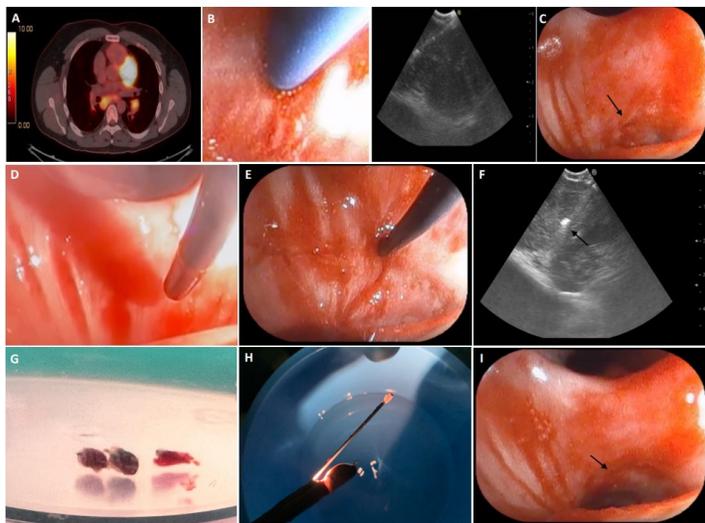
PET-CT scan showed an increased FDG uptake at stations 7 and 11L (A). Performing EBUS-TBNA in station 7; TBNA needle sheath (B). Puncture site made by TBNA needle, black arrow (C). Tip of the cryo-probe approaching the puncture site (D), and a tip of the cryo-probe completely inside the node (E). EBUS image showing the tip cryo-probe within the lymph node, black arrow (F). Tip of the probe has the lymph node tissue obtained by cryo-nodal biopsy (G). Bronchoscopic view of the puncture site after performing cryo-nodal biopsy, black arrow (H). Samples obtained from transbronchial mediastinal cryobiopsy (I).
